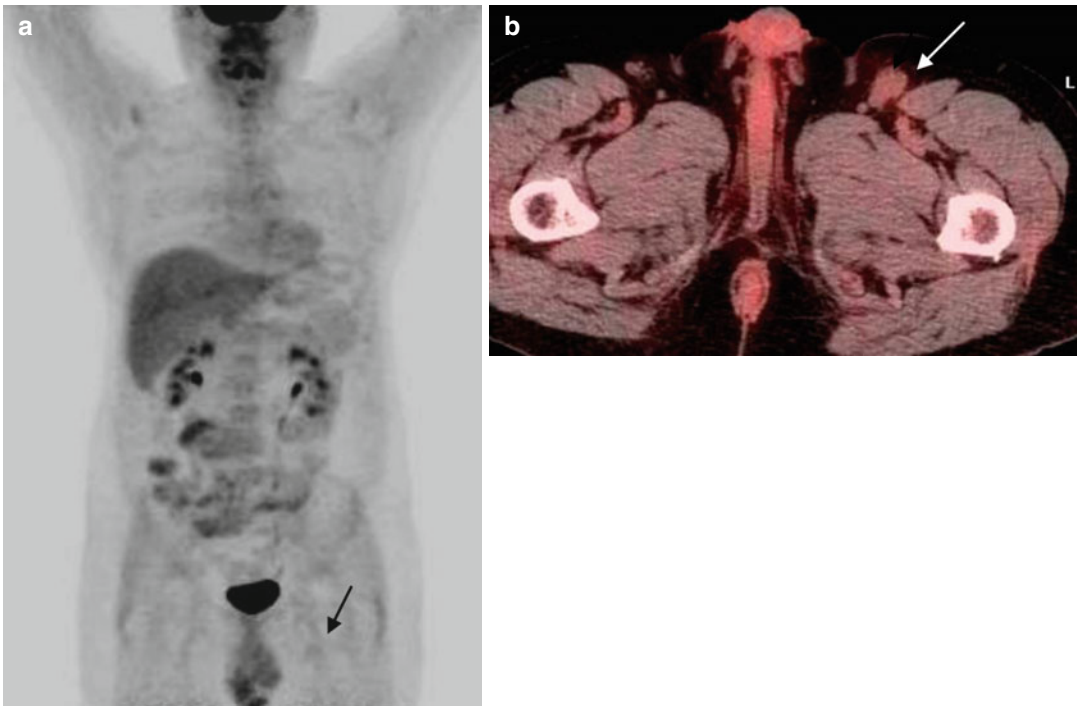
(a, b) MIP-PET and fused PET/CT – end of treatment: Mild (lower than the mediastinum) FDG uptake at a left inguinal nodal residue (black arrow in MIP and white arrow in the fused images)
